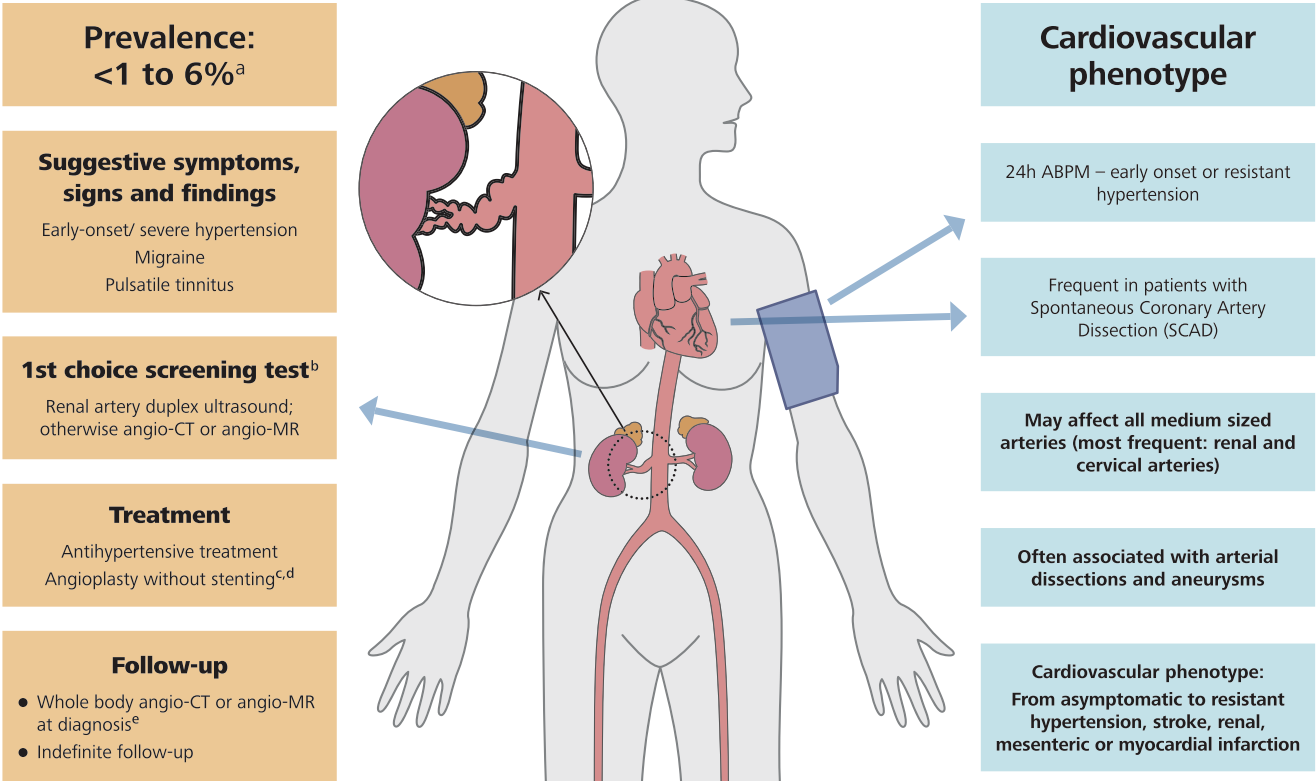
B Fibromuscular Dysplasia (FMD). (a) FMD occurs predominantly in young or middle-aged women. However it may be diagnosed at any age, both in women and men. Renal FMD is the second cause of renovascular hypertension after atherosclerotic renal artery stenosis. (b) Two subtypes of FMD have been described: multifocal FMD (80–90% of cases) and focal FMD (10–20% of cases). The characteristic lesion of multifocal FMD is the “string of beads”, characterized by alternating areas of stenosis and dilatation in the mid and distal portions of the artery. Focal FMD is characterized by focal stenosis of variable length, which may occur in any part of the artery and requires exclusion of atherosclerosis, inflammatory or genetic arteriopathies. (c) In a meta-analysis, the rate of cure of hypertension after angioplasty was 36% (range 14–85%) but may be much higher in younger patients with recent onset hypertension. Angioplasty deserves also to be considered in patients with renal FMD and resistant hypertension. (d) Stent kinking and fracture have been reported in the setting of renal FMD. Accordingly, stenting is usually not recommended in renal FMD and reserved for treatment of flow-limiting per-procedural dissection or in case of renal artery aneurysm. (e) In over 50% of cases, patients with renal FMD have lesions in one or more other arterial beds (multivessel FMD). Patients with FMD also often have arterial dissections, aneurysms or marked arterial tortuosity. For these reasons, it is recommended to perform at least once a life-time head to pelvis angio-CT or if contraindicated MR-angiography in all patients with FMD.
